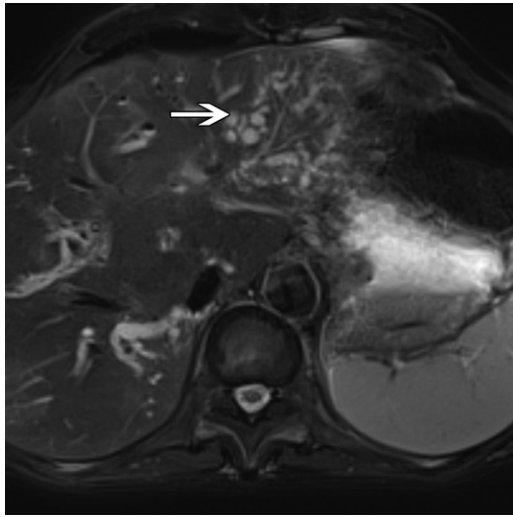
PSC in a 46-year-old woman. Axial T2-weighted fat-saturated MR image shows diffuse contour irregularity throughout the liver. Diffusely irregular calibers of the bile ducts are noted throughout the liver, with predominant involvement of the lateral segment of the left hepatic lobe (arrow).
